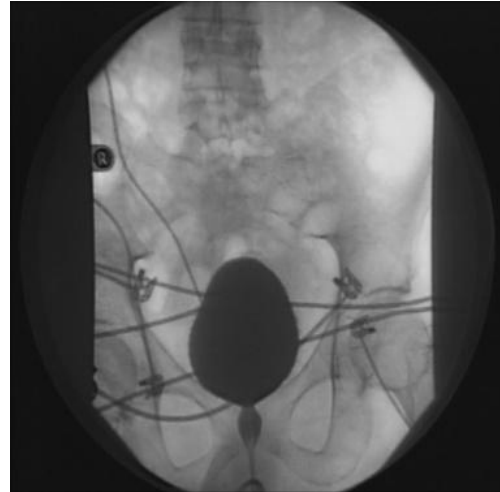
X-Ray image of the bladder and intraurethral catheter. The IU catheter is visible only outside the bladder, since the contrast fluid is radio-opaque.
